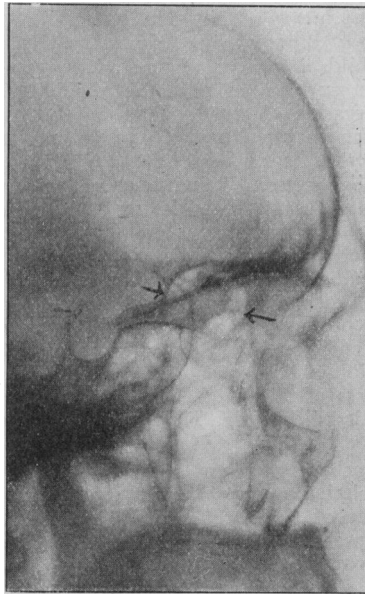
Radiograph showing an erosion described by Dr. Dandy as typifying a case of "Schüller-Christian disease".
